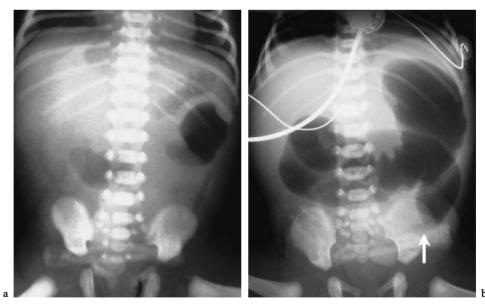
Jejunal atresia. a Supine radiograph shows an airless abdomen. b Aspiration and insufflation of air through a nasogastric tube was performed and adequately demonstrates the point of obstruction (*arrow*). Massively dilated loops of jejunum but only about three "bubbles" give indication of a high obstruction
